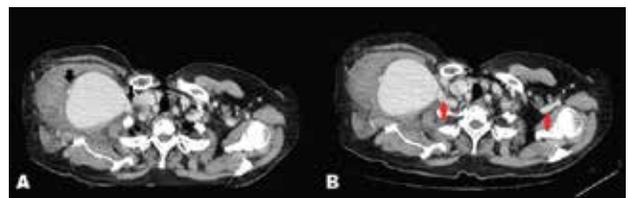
Post Contrast Contiguous axial CT sections showing aneurysm [black arrows in Fig. A.] Contralateral subclavian artery also visualized [red arrows in Fig. B]
